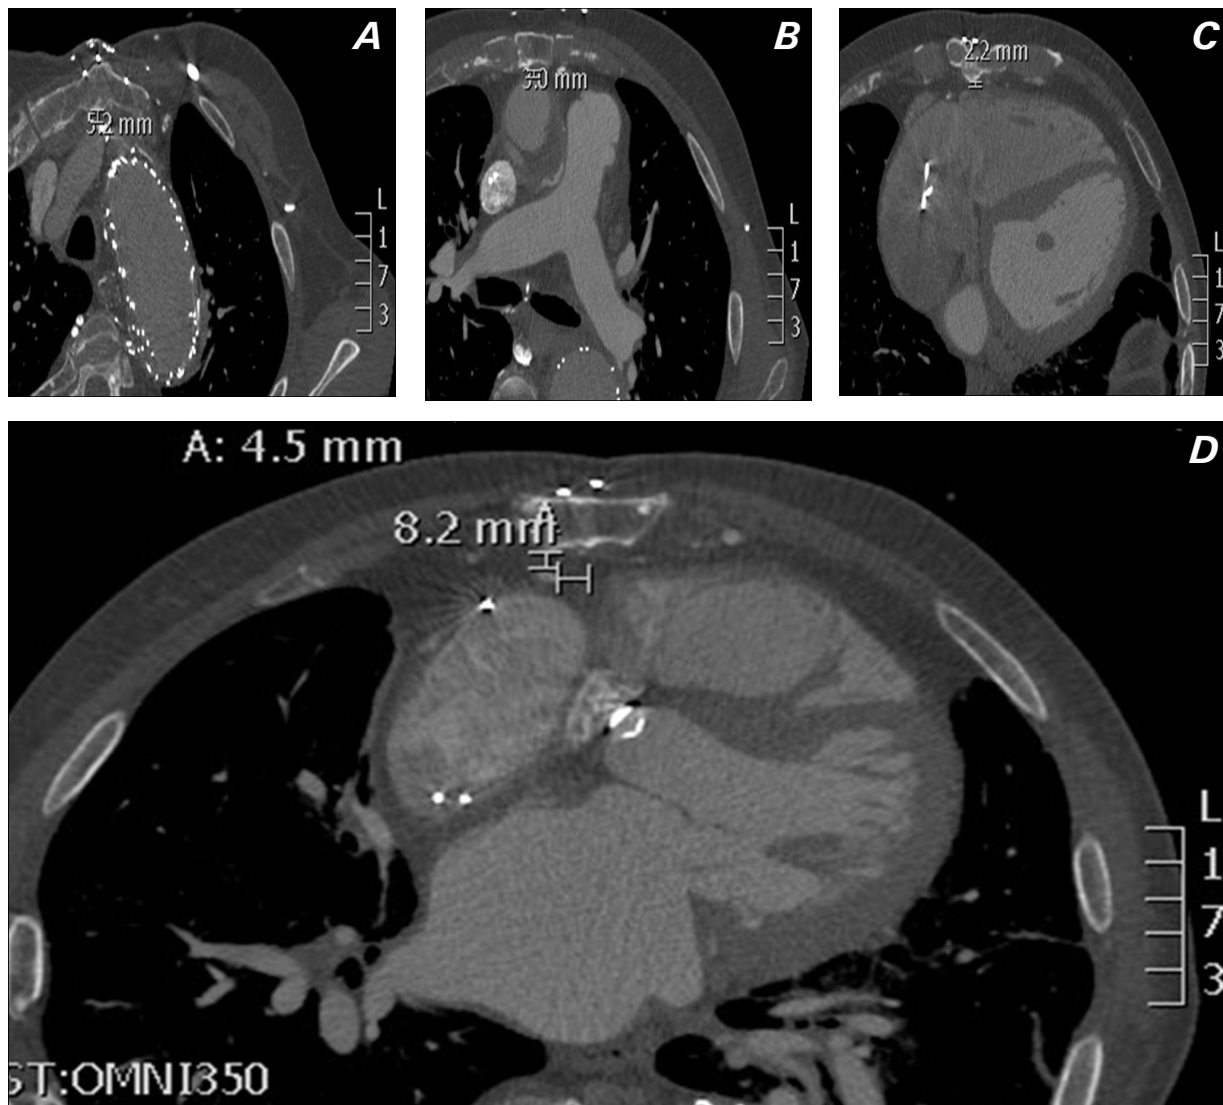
A computed tomography scan showing cardiac structures and prosthetic grafts from previous aortic surgeries adhered to the posterior table of the sternum. A) A chronically thrombosed left brachiocephalic vein containing pacing leads lies 5 mm below the manubrium. B) The ascending aortic graft lies 3 mm below the upper third of the sternal body. C) The anterior free wall of the right ventricle lies 2 mm below the suprasternal junction. D) The right coronary artery lies 5 mm below the inferior third of the sternum and 8 mm to the right of the sternal midline.
